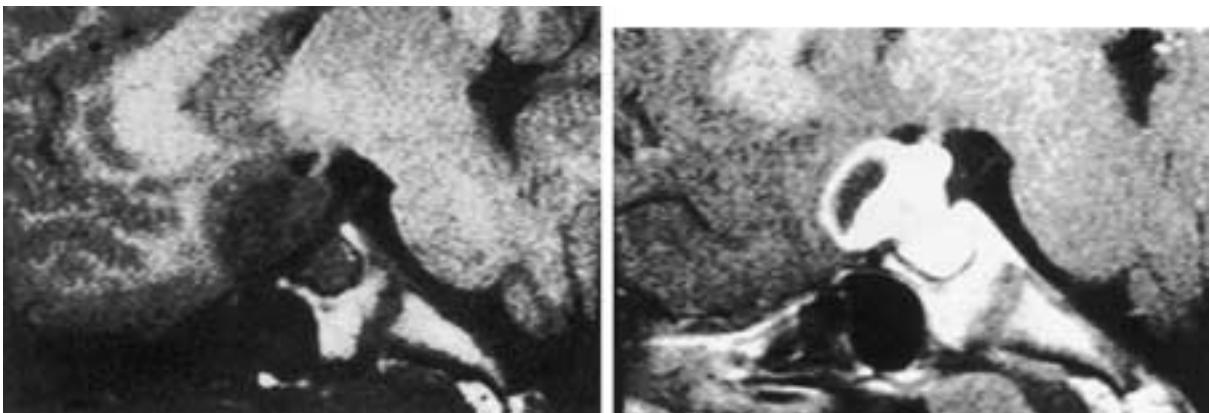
Craniopharyngioma in a 10-year-old male with evidence of clinical involvement of the left optic tract in the form of an incongruous homonymous hemianopsia. A, Sagittal T1-weighted MR image before gadolinium enhancement shows a soft-tissue mass both within and above the sella turcica; the mass abuts on the optic tract. B, T1-weighted MR image following gadolinium injection shows enhancement of the partially cystic mass.
